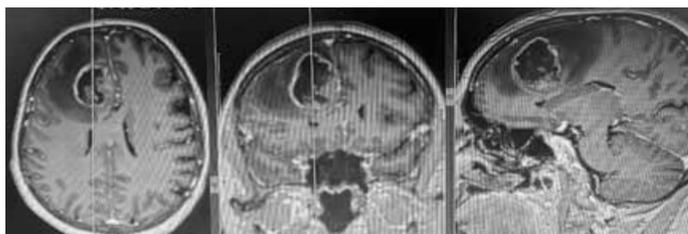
Preoperative MRI postcontrast series of an infiltrative solid/cystic right frontal parasagittal HGG
